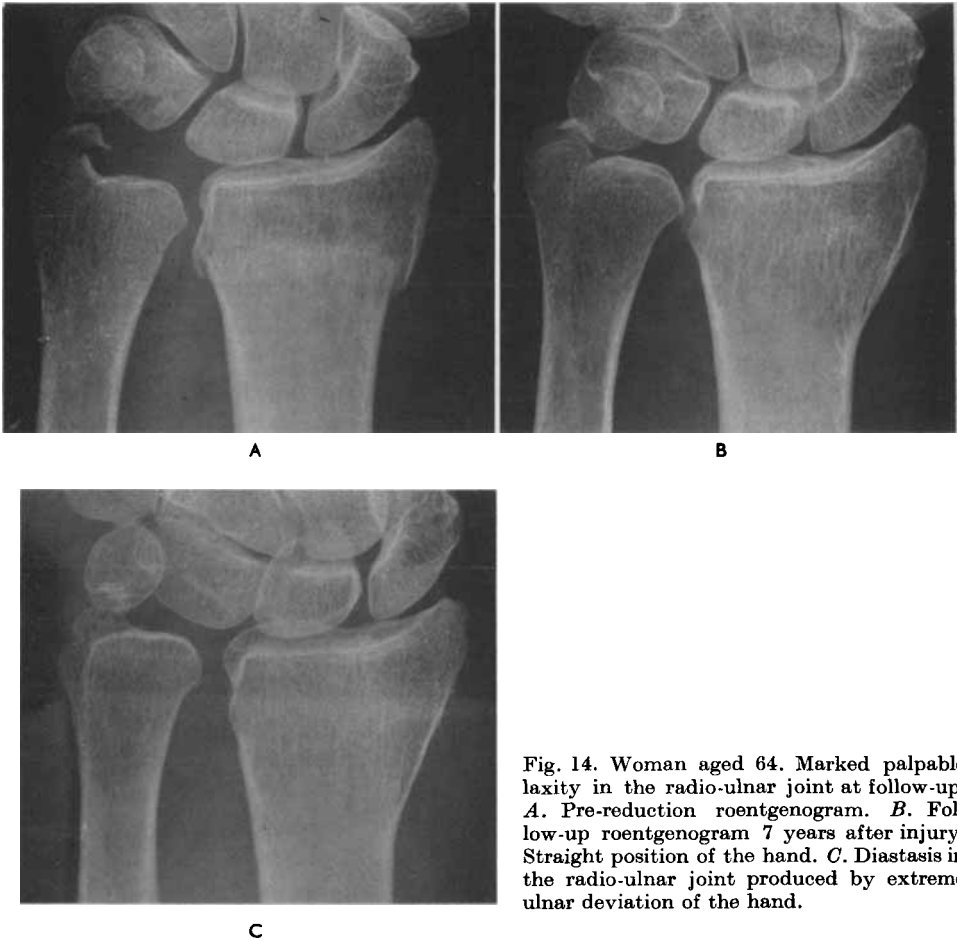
Woman aged 64. Marked palpable laxity in the radio-ulnar joint at follow-up. *A.* Pre-reduction roentgenogram. *B.* Follow-up roentgenogram 7 years after injury. Straight position of the hand. *C.* Diastasis in the radio-ulnar joint produced by extreme ulnar deviation of the hand.
